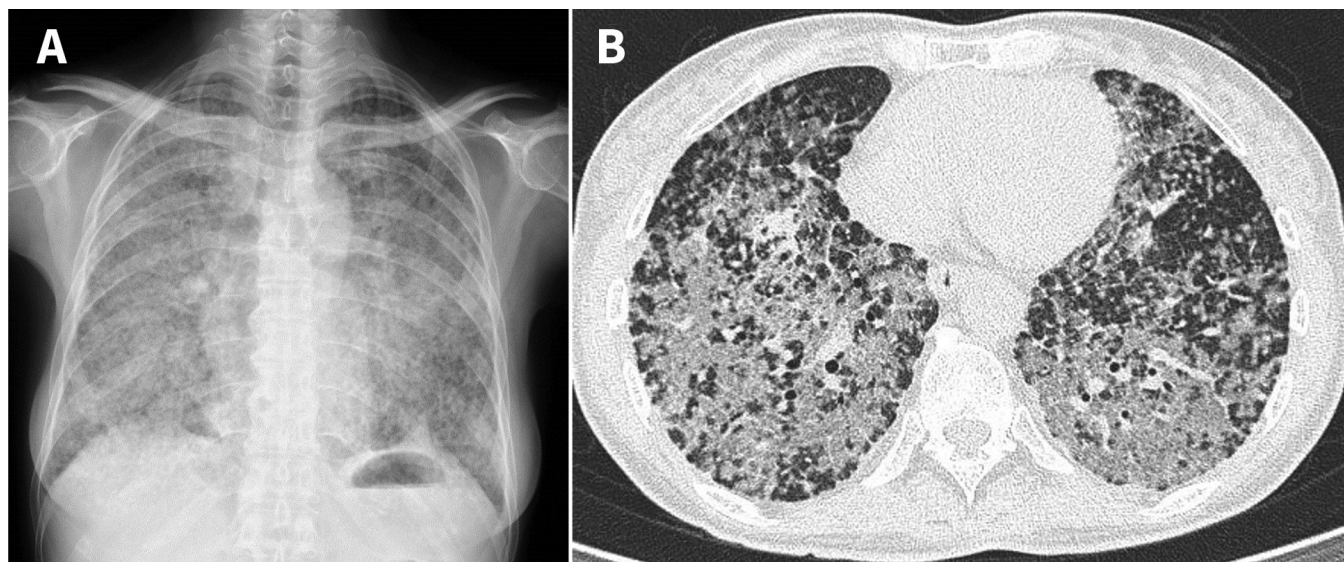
(A) Chest radiograph and (B) computed tomography scan of a 55-year-old woman with lung adenocarcinoma. Both images show a miliary pattern with diffusely distributed, ground-glass opacities overlaying multiple small nodules throughout all lung fields.
